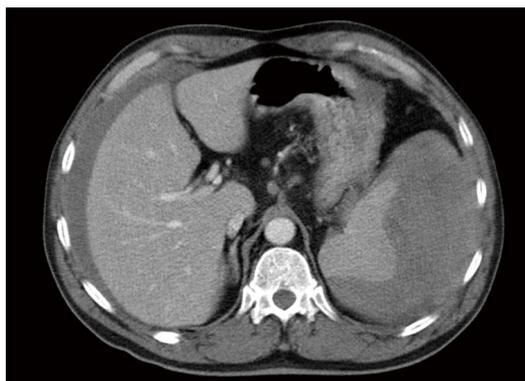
Abdominal CT scan showing a splenic subcapsular haematoma of 15 cm × 9 cm.
